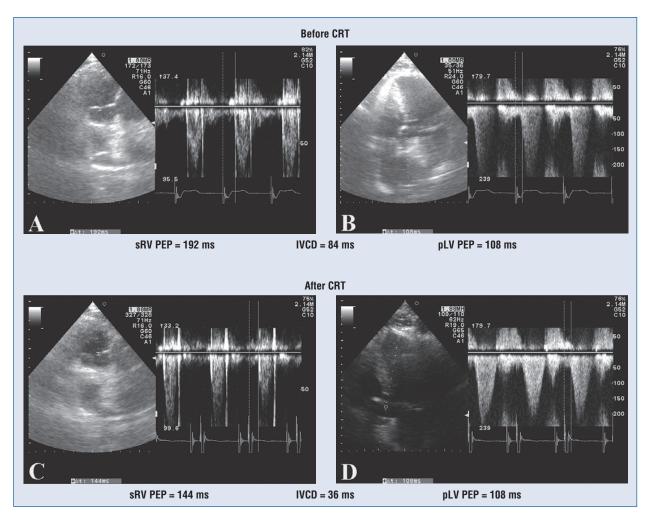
Echocardiography; A, C. Right-sided parasternal modified projection; B, D. Five chamber apical projection. Inter-ventricular dyssynchrony features are shown. The interventricular conduction delay (IVCD) measurement in the text; sRV — systemic right ventricle; pLV — pulmonic left ventricle; CRT — cardiac resynchronization therapy.
